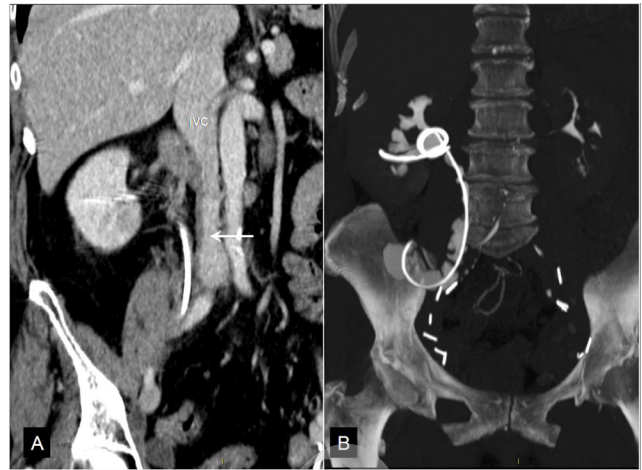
Computed tomography-urography performed prior to the ureteral stent removal, note the complete healing of the inferior vena cava wall.
